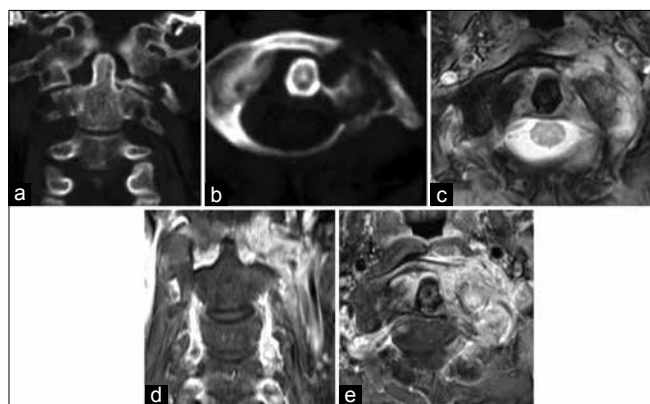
Langerhans cell histiocytosis of C1 lateral mass in a 45-year-old man with neck pain. Coronal (a) reformatted computed tomography images scan revealed that the left lateral mass of C1 was depressed. Axial (b) showed the lytic bone destruction of the left lateral mass and the bone cortex was not complete. Axial (c) T2-weighted fast spin-echo magnetic resonance images showed the bone destruction of C1 lateral mass with soft mass formation. On coronal (d) and axial (e) gadolinium-enhanced T1-weighted image showed the significant enhancement of C1 lateral mass and adjacent soft mass
